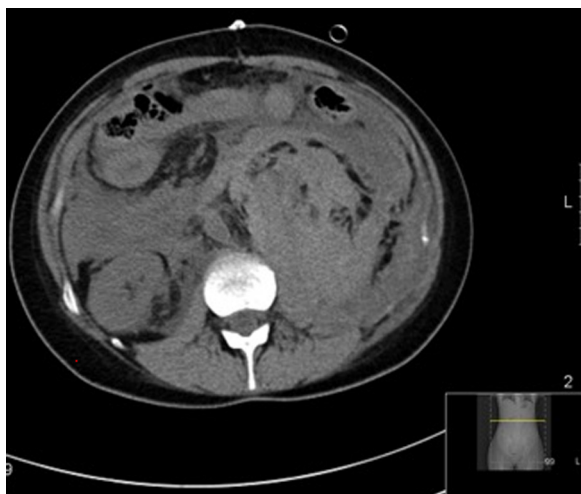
Unenhanced CT demonstrating a large retroperitoneal haematoma surrounding the left renal artery.
